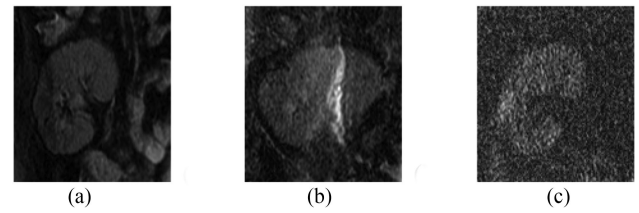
Coronal cross-sections of raw DW-MRI samples showing (a) similar intensities of kidney and surrounding tissues at b_0 , (b) inter-patient anatomical differences at b_0 , and (c) image noise at higher b -values (b_{1000}).
